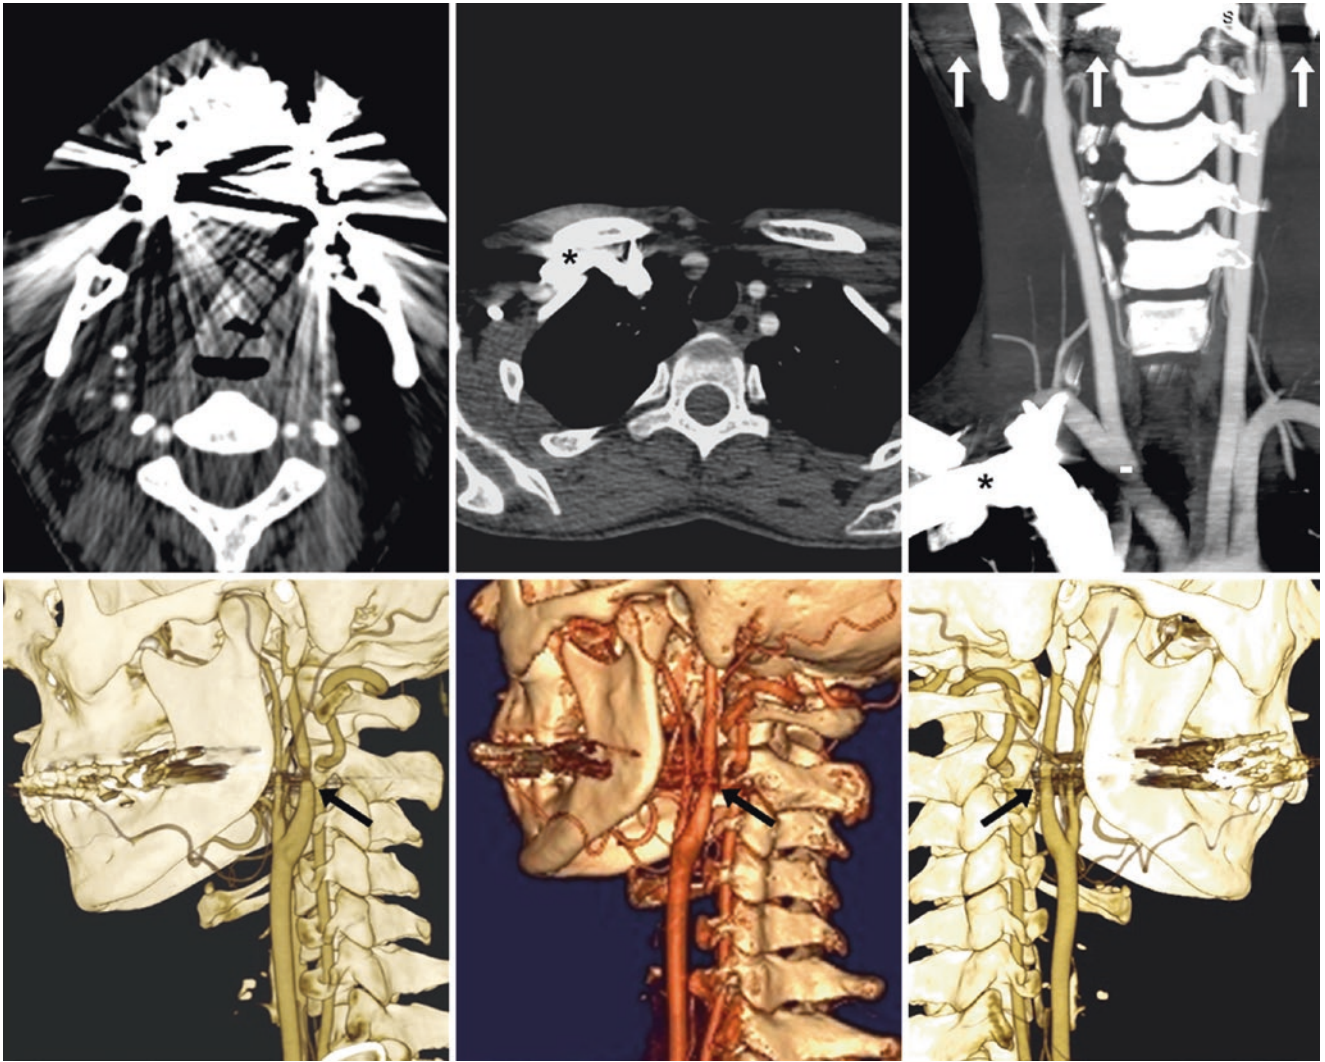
30-year-old with a neck CTA limited by streak artifact from dental amalgam. *Top row:* streak artifact (*arrows*) obscures the ICA origins, as shown on axial images (*left and middle*), and on a coronal MPR (*right*), causing pseudo-stenoses. There is also streak artifact at the thoracic inlet from contrast persistence within the right BCV and SCLV
